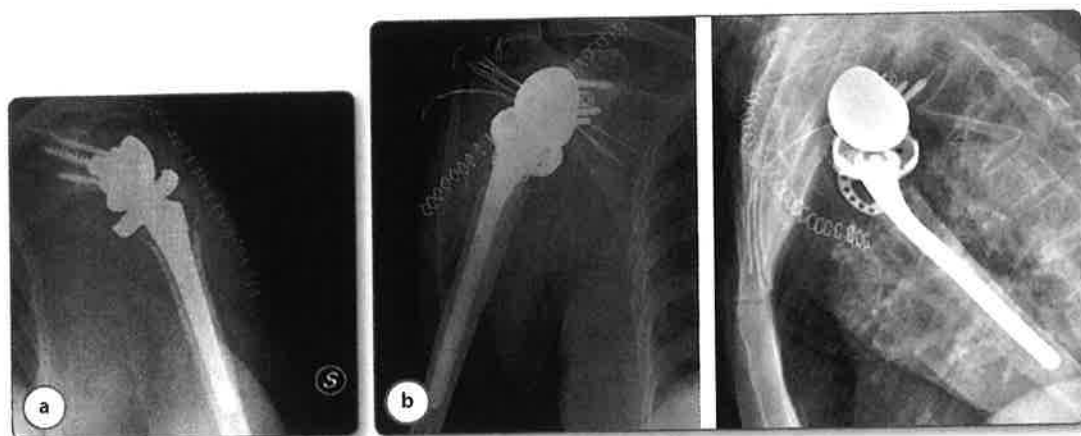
(a) Postoperative radiograph control with non-cemented stem implant. (b) Postoperative radiograph control with cemented stem implant.
